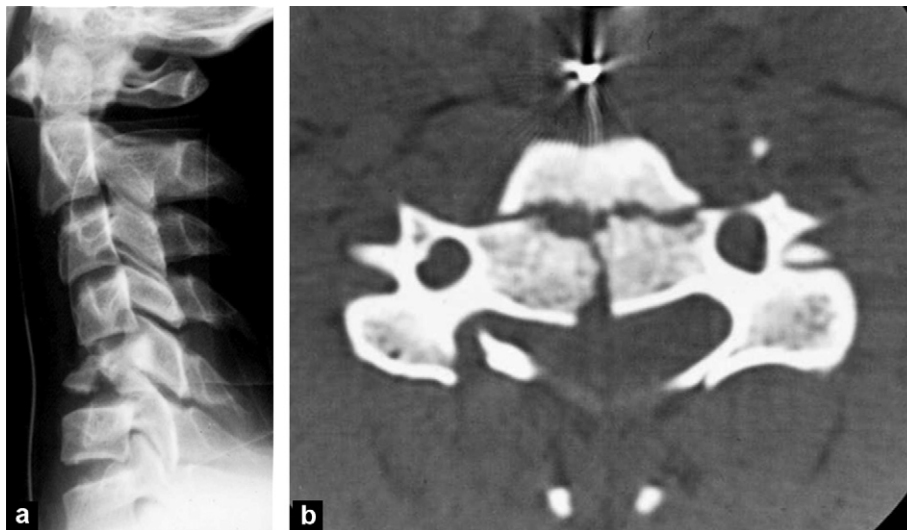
Tear drop fracture. a: lateral radiograph: avulsion of the anterior-inferior corner of C5; b: CT(axial reformat) confirms the tear drop by showing the components, sagittal and coronal, two fracture lines with three fragments.
